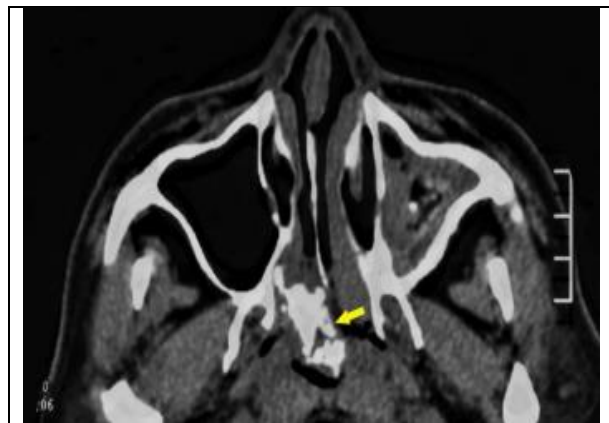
CT axial scan of the soft tissue window revealed that osseous trabeculae (yellow arrows) in polyps accessed the nasopharynx from the nasal cavity via the choana.
